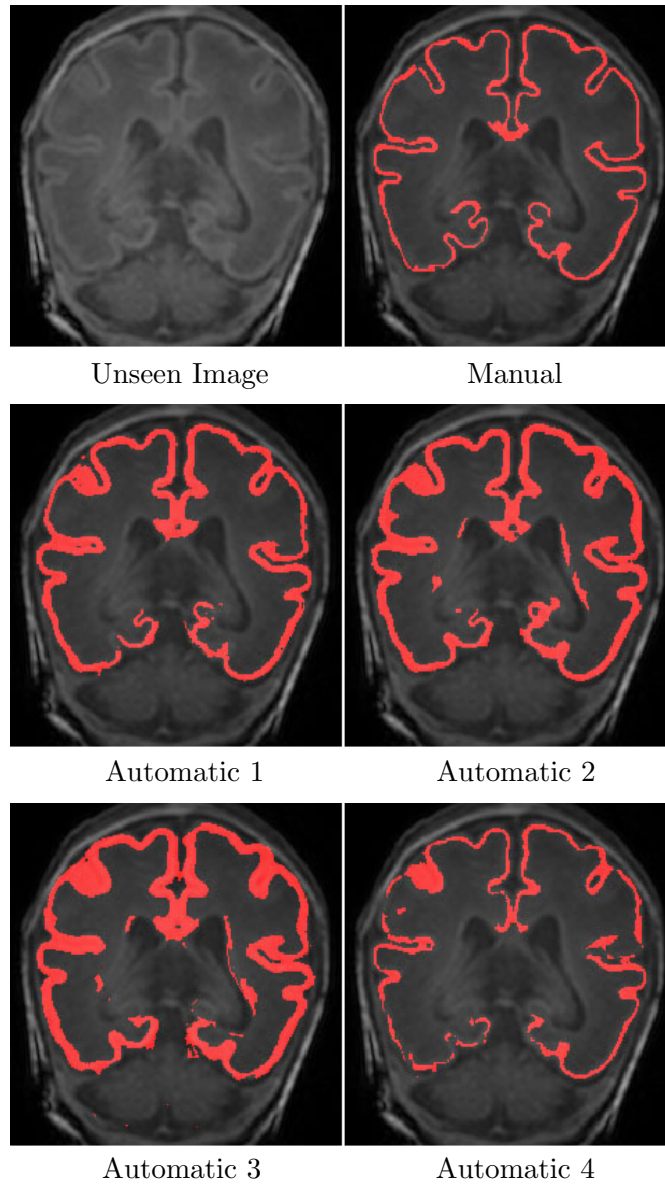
Example GM segmentations from the NeoBrainS12 (2012) challenge of a neonatal MRI acquired at 30 weeks PMA (data from <http://neobrain12.isi.uu.nl>). The T2 image and the corresponding manual segmentation can be observed in the top row. The second and third row display the GM segmentation produced by four different automatic techniques.
